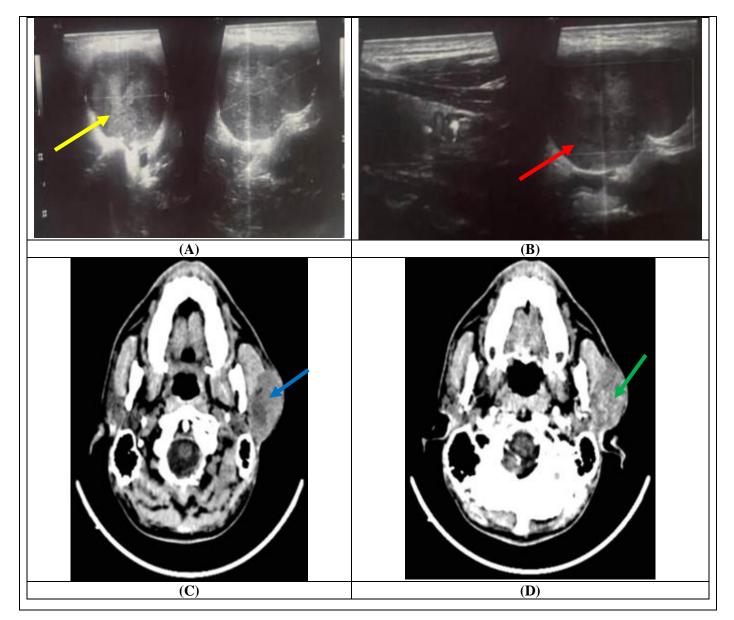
55 years male patient complained of painless swelling in left parotid region 5 years ago, neck ultrasound done showing well-defined soft tissue mass lesion seen within left parotid with rim of parotid tissue surrounding it circumferentially (A yellow arrow) with faint internal vascularity on color Doppler study (B red arrow), CT neck with IV contrast showing diffuse swelling of the left parotid gland with solid lesion showing heterogeneous contrast enhancement (C without contrast blue arrow) (D with contrast green arrow).diagnosed as left parotid gland pleomorphic adenoma and final diagnosis was left parotid gland pleomorphic adenoma (Mixed salivary gland tumor).
